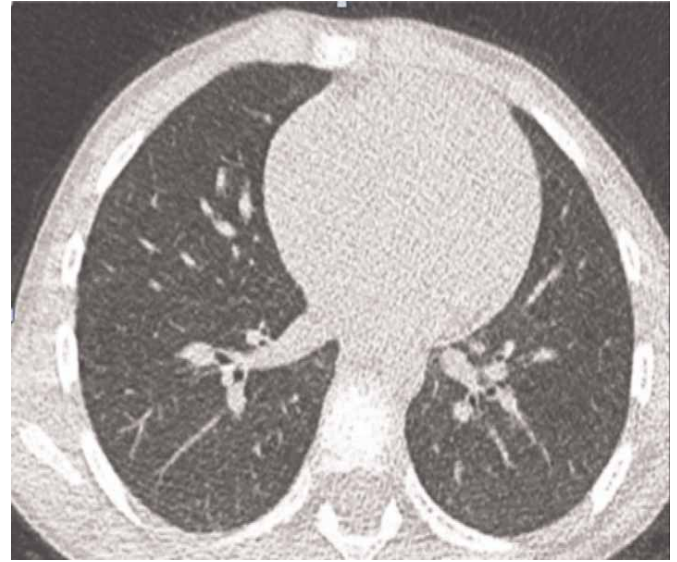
Computed tomography 6 years after initial presentation.
